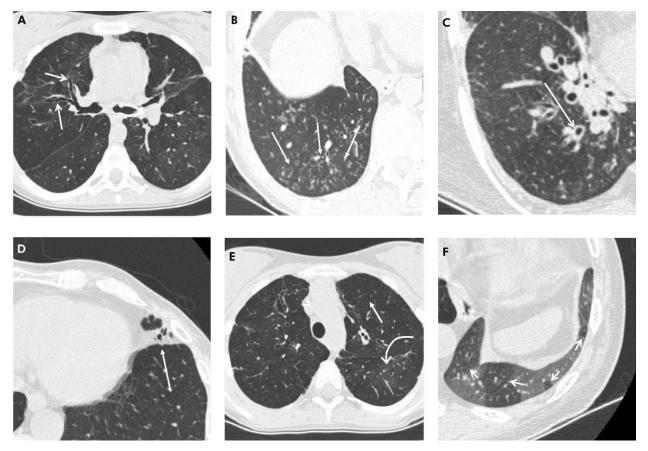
Representative CT images showing the CT_{BO} scoring system abnormalities. A collection of transaxial 1.25 mm CT sections in different patients viewed at lung window and level setting (width 1500 HU, level -500 HU) showing (A) bronchiectasis (arrows) identified by the absence of normal bronchial diameter tapering; (B) peripheral mucus plugging shown as multiple centrilobular nodules (arrows); (C) dilated bronchus with associated wall thickening (arrow); (D) lingular consolidation (arrow) shown as an area of increased density obscuring the underlying pulmonary vasculature; (E) generalised mosaic pattern in both upper lobes shown by areas of decreased attenuation and vessel size (straight arrow) compared with regions of normal attenuation and normal vessel size (curved arrow); and (F) expiratory image showing areas of air trapping (arrows).
